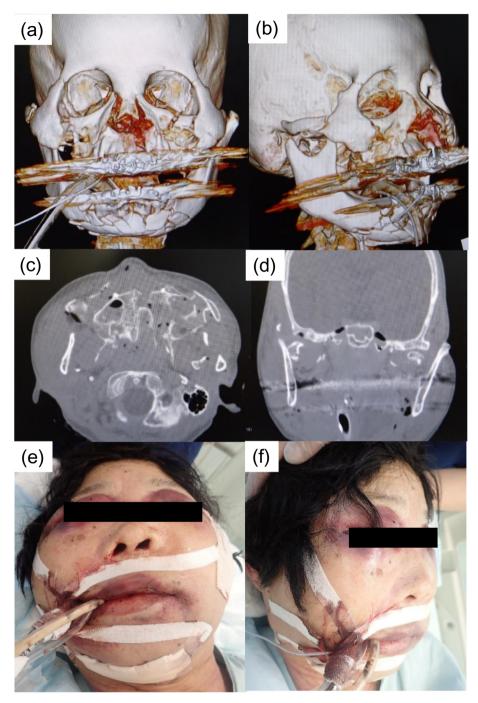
Frontal (a) and right oblique views (b) of head three-dimensional computed tomography (CT) on admission. Axial (c) and coronal views (d) of midface CT on admission. Frontal (e) and right oblique appearance (f) after intubation on admission. An expanded facial width and flattening of the nose were observed.
